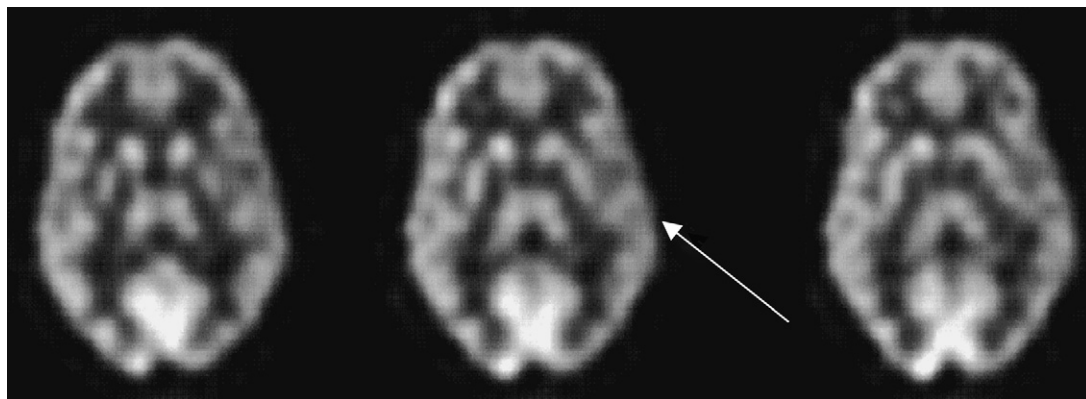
FDG-PET scan of a 43-year old woman who suffered a head injury 2 years before this study and now has cognitive and memory dysfunction and language problems. This scan demonstrates hypometabolism of the entire left hemisphere (arrow) relative to the right. *Abbreviation:* FDG-PET, fluorodeoxyglucose–PET.
